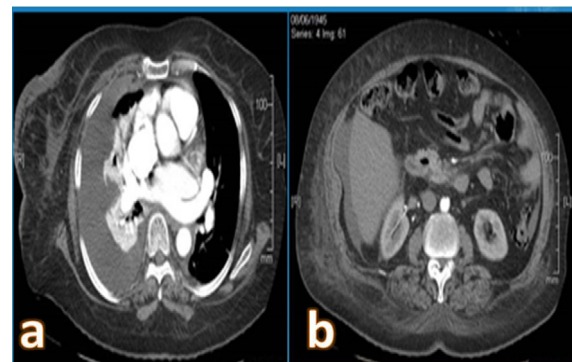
(a) CT chest revealed significant right side pleural effusion with underlying lung collapse, right lateral chest wall edema & right breast edema. (b) CT abdomen revealed mild ascites & right lateral abdominal wall edema.
